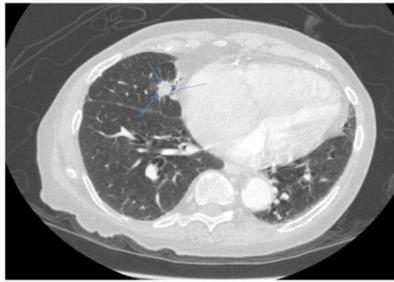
CT scan showing right middle lobe lung nodule: Blue arrows outline the mass.
